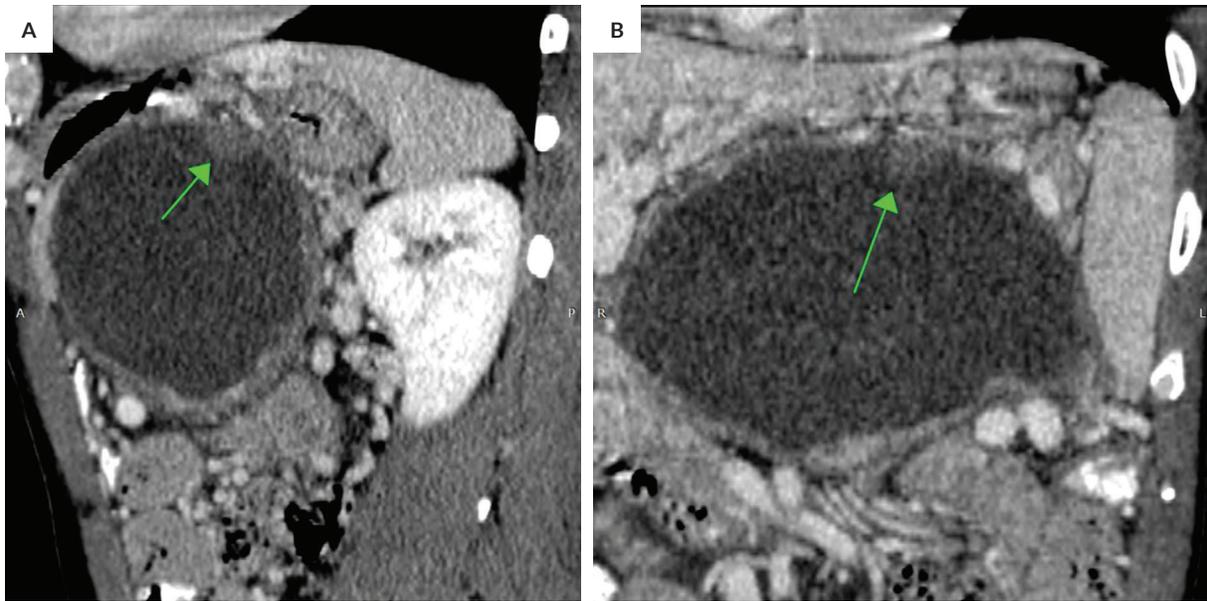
Sagittal (A) and coronal (B) views of the contrast-enhanced CT scan showing an enhancing peripheral solid component (green arrows) along the superior aspect of the pancreatic mass.
